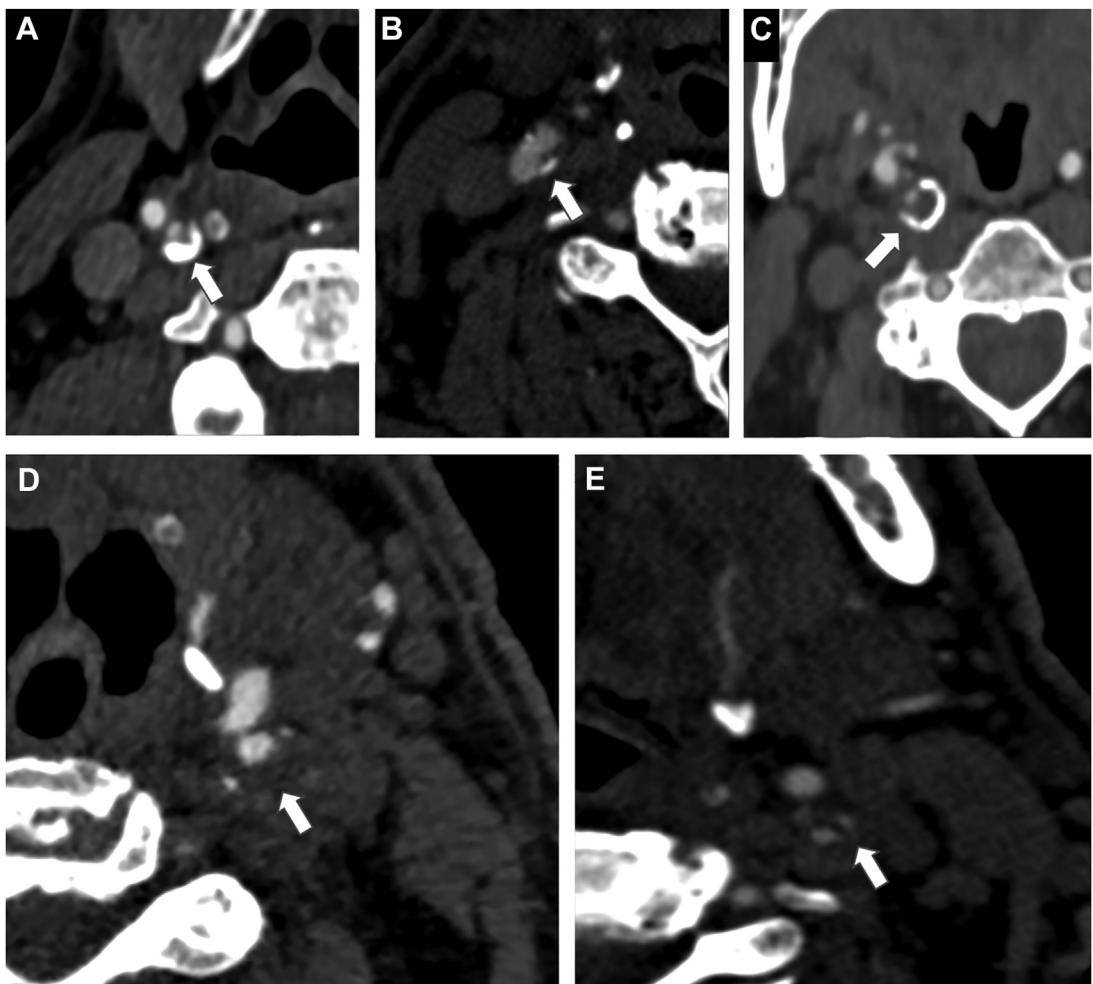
Examples of different “high-risk” features of carotid plaque using CT. Panel A–C demonstrates different carotid plaque calcifications, in particular, heavy calcified plaque (arrow in A), microcalcification (arrow in B), and “positive rim” sign, defined as plaque with adventitial calcification (<2 mm thick) and internal soft plaque (>2 mm thickness) (arrow in C). CTA axial image (D) shows a hypodense plaque (HU value = 15) indicating the presence of LRNC (arrow). CTA axial image (E) demonstrates ulcerated stenosis in the postbulbous left internal carotid artery.
